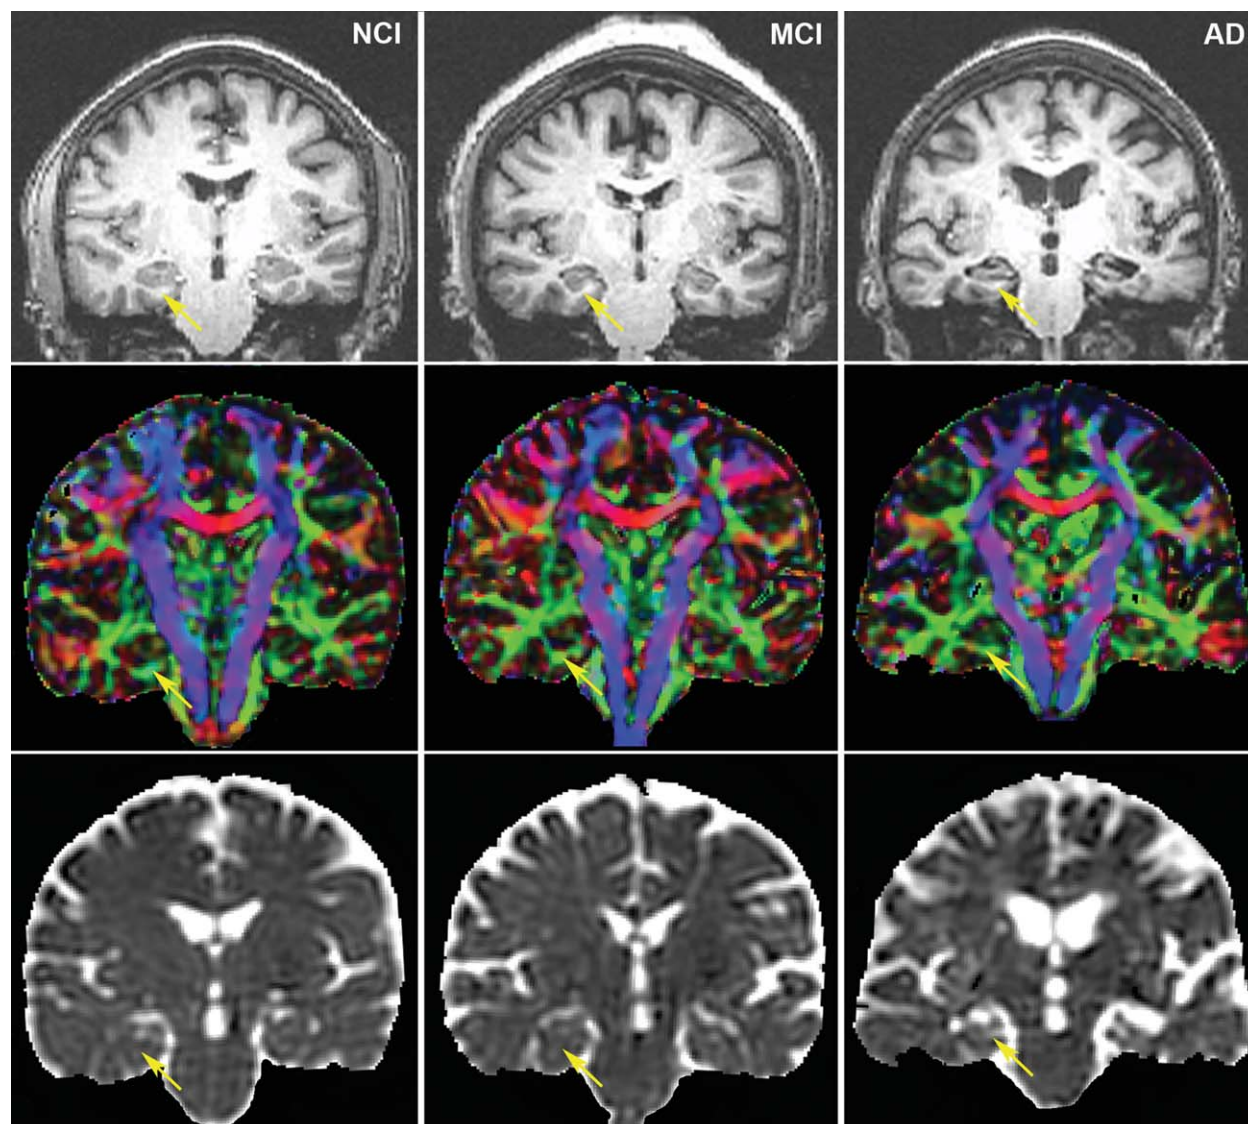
Individual examples of structural MRI images depicting the white matter in the parahippocampal region. *Left column:* control subject. *Middle column:* MCI subject. *Right column:* Alzheimer's disease subject. The first row of images depicts coronal T1-weighted images obtained from the MPRAGE sequence. Note the significant degree of atrophy, reflected by the enlargement of the lateral ventricles and sulci, present in the Alzheimer's disease subject. The second row of images represents the directionally encoded FA color maps obtained in the oblique-coronal plane in the same subjects. The red color indicates a left-to-right direction; blue, superior to inferior; green, front to back. Note the decrease in the intensity of the signal in the AD subject compared with control. The third row of images depicts the mean diffusivity maps obtained in the oblique-coronal plane. Arrows point to the location of the parahippocampal white matter region in the right hemispheres.
